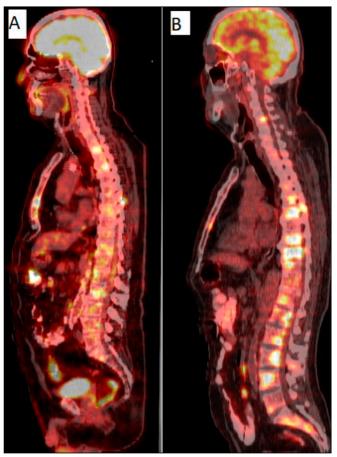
PET/CT imaging showing widespread bone metastases (A) case 1, (B) case 2
